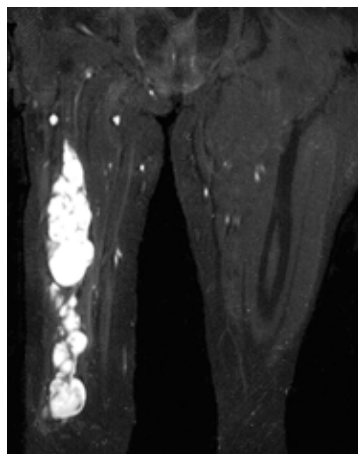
Coronal T₂-weighted magnetic resonance imaging of the affected thigh shows multiple cystic lesions about the sciatic nerve and its branches.
